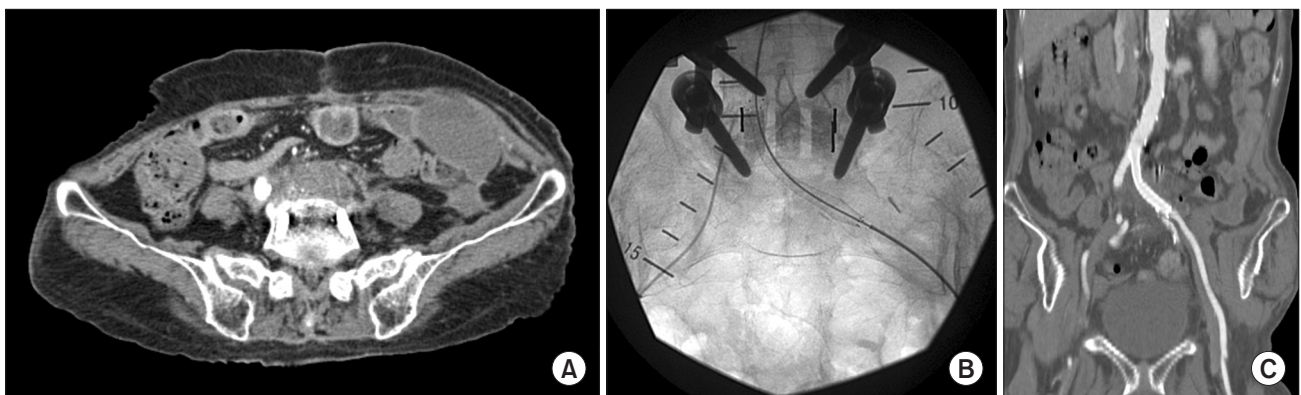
(A) Twenty three months after discectomy. Computed tomography (CT) angiogram shows thrombosed pseudoaneurysm of left common iliac artery with total occlusion. (B) Covered stent deployment was performed. (C) Three days after intervention, follow-up CT shows complete exclusion of pseudoaneurysm.
